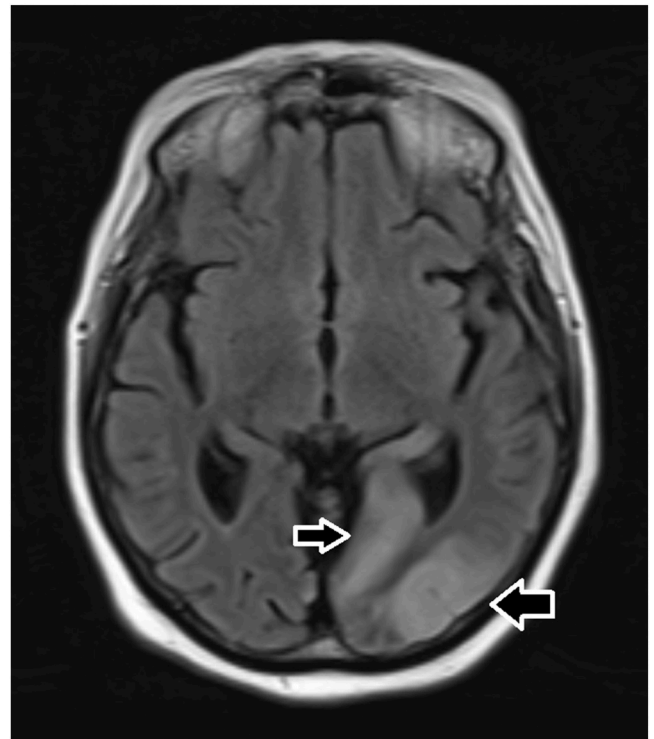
Brain MRI with IV contrast, FLAIR 16/28, arrow showing emboli in the left occipital lobe.
